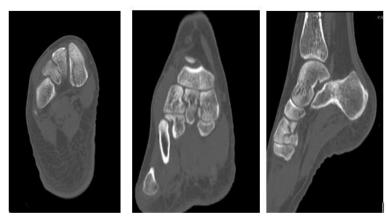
CT axial, coronal & sagital sections show undisplaced fracture medial cuneiform bone
